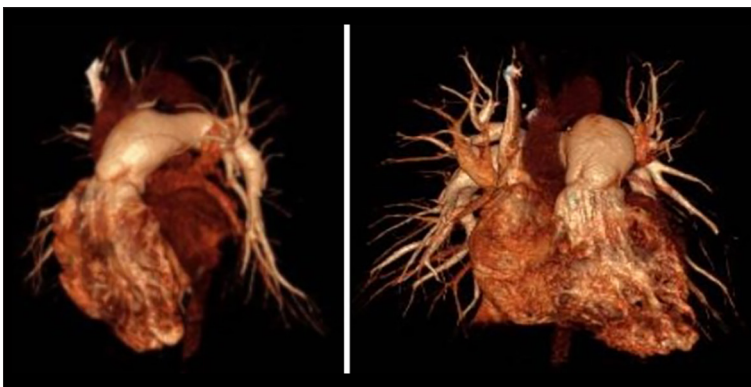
Three-dimensional (3D) volumetric cardiac computed tomography angiography, shown in the left anterior oblique and right anterior oblique views, depicts pronounced ectasia of the pulmonary trunk and branches with smooth-contoured right atrial enlargement, indicating chronic right-sided volume overload.
